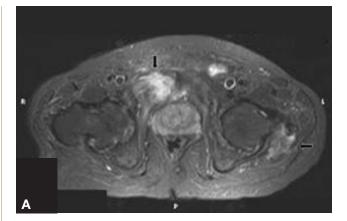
Computed tomography shows (A) osteolysis at right rami and 5×4×4-cm soft-tissue mass with attenuation similar to that of skeletal muscles (similar fragmentation and osteolysis are seen in left trochanteric region) and (B) longitudinal fractures on both sides of sacral body parallel to sacral alae and sacroiliac joints.
